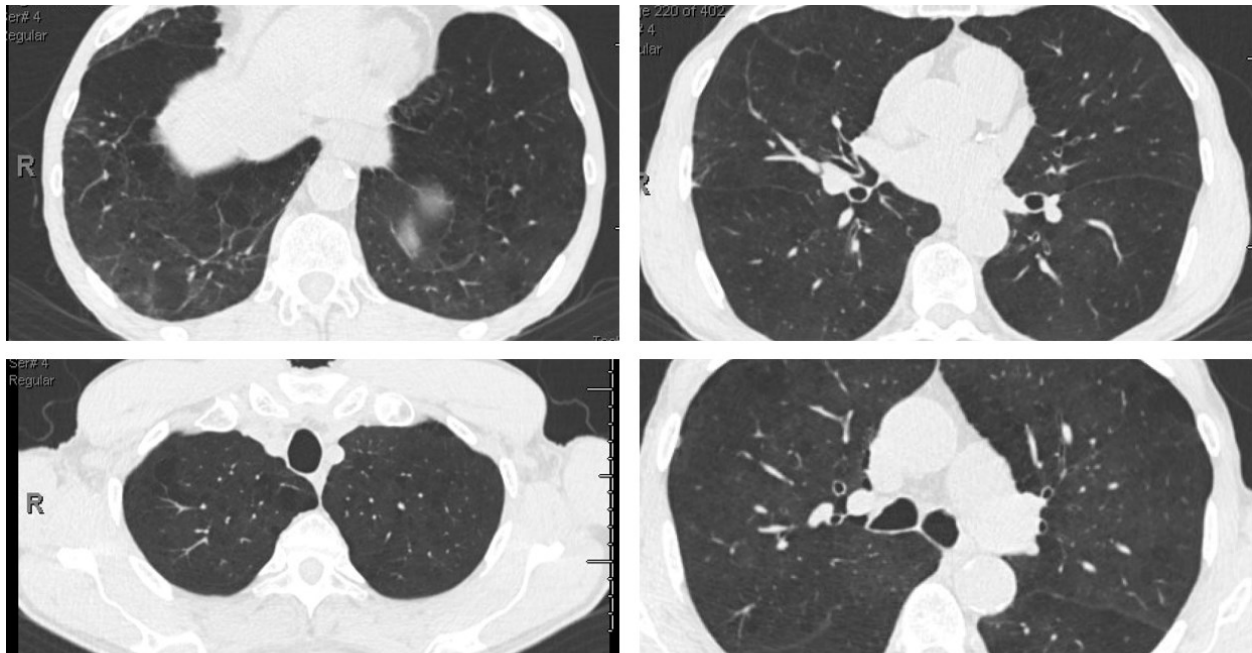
Case 2 - Computed Tomography Chest Pre-BLVR
